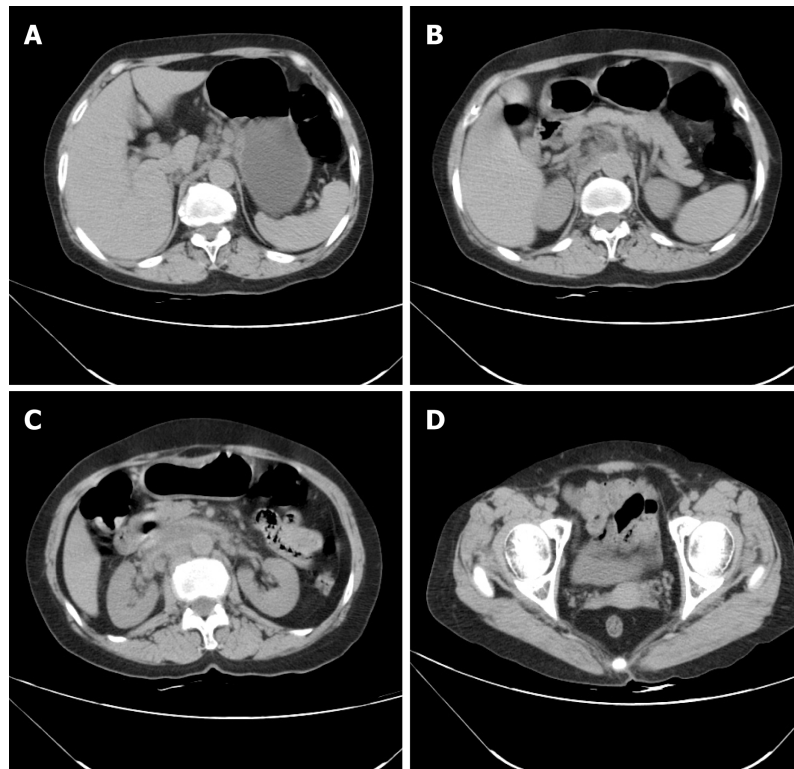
Computed tomography findings. A-D: Computed tomography images not revealing substantial evidence for the existence of malignant lesions in the gastrointestinal wall.
